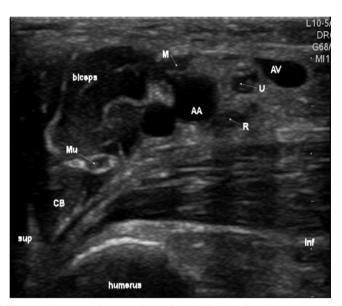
Ultrasound image of the distal axilla showing the relationship of the terminal nerves of the brachial plexus to the axillary artery (AA) and axillary vein (AV). The musculocutaneous nerve (mu) lies in a plane between biceps and coracobrachialis (CB) muscles and frequently has a partially hypoechoic core which is often also a feature of the ulnar nerve (U). The median nerve (M) lies in typical position with the radial (R) located below the ulnar nerve in the 5 o'clock position.
